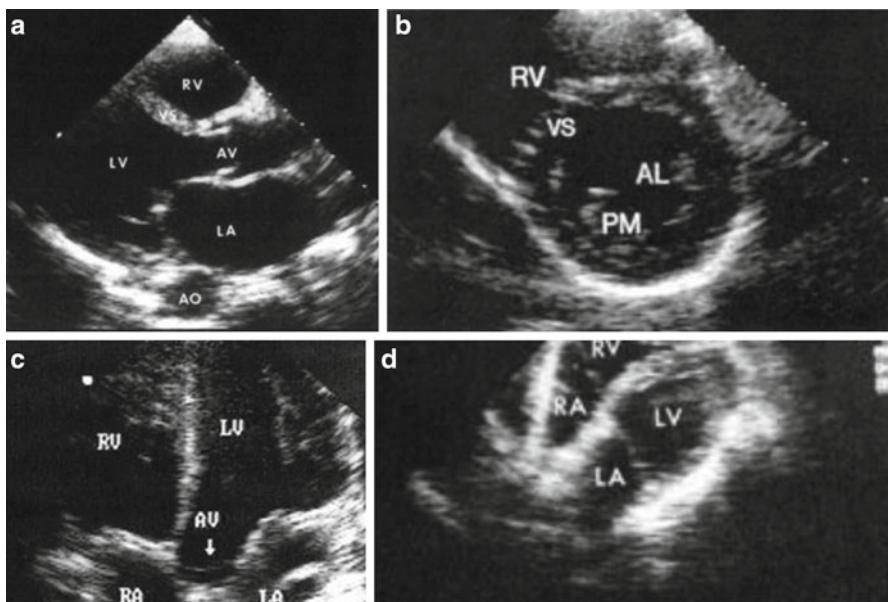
Four basic views: (a) left parasternal long axis, (b) left parasternal short axis, (c) apical four chambers, and (d) subcostal
